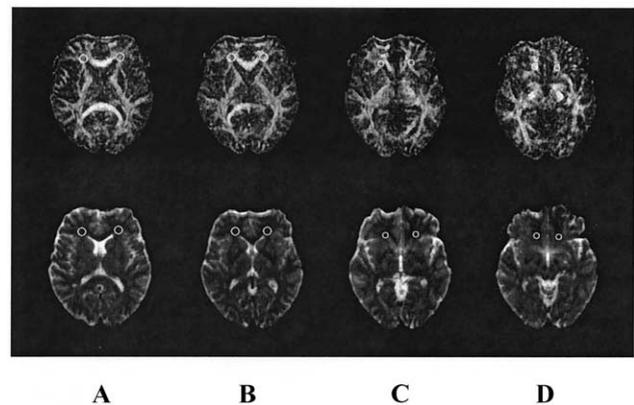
Region of interest placement on the fractional anisotropy maps (top) and on corresponding anatomical T2-weighted images (bottom) of the frontal white matter regions: (A) 10 mm above, (B) 5 mm above, (C) 0 mm below, (D) 5 mm below the AC-PC plane. AC-PC, anterior commissure–posterior commissure plane.
